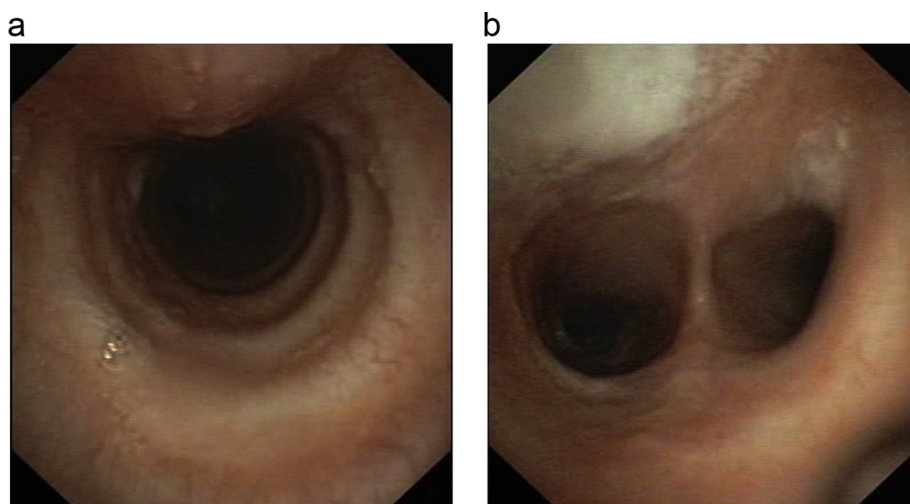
Mounier-Kuhn syndrome: tracheomegaly (a) and right main bronchus bronchomegaly (b) in an eleven-year-old boy with a history of daily wet cough for two years. A chest CT scan showed cylindrical bronchiectasis at both lower lobes bronchi and a diverticulum at the right main bronchus. BAL culture was positive for non-typable *Haemophilus influenzae*, *Streptococcus pneumoniae* y *Moraxella catarrhalis*.
